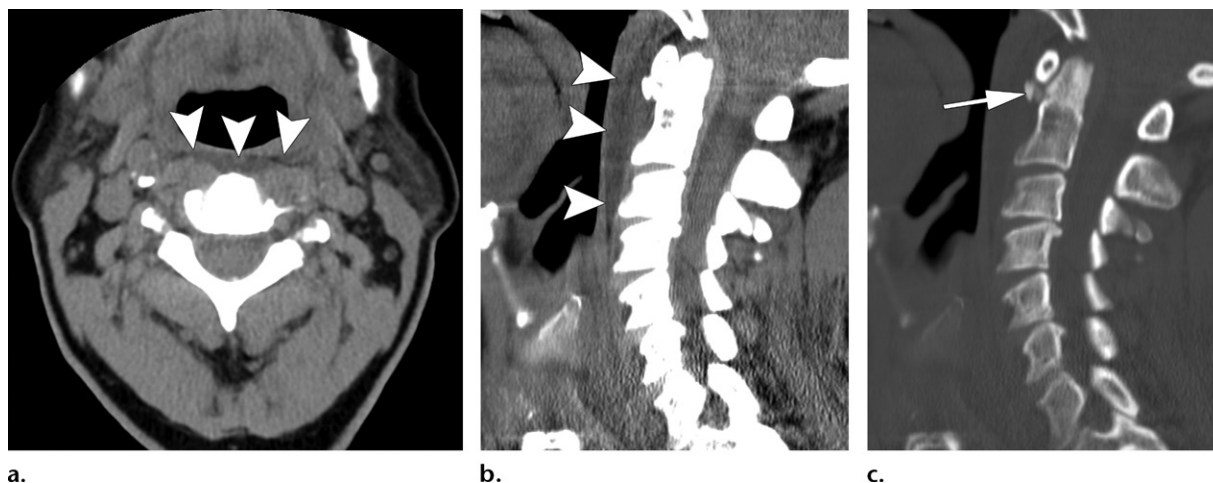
Retropharyngeal edema due to calcific tendinitis of the longus colli in a 71-year-old woman. (a, b) Axial (a) and sagittal (b) nonenhanced CT images show retropharyngeal edema (arrowheads). Note the tapered superior and inferior margins in b. (c) Sagittal nonenhanced CT image (bone window) shows calcification (arrow) inferior to the anterior arch of C1, in the typical location for calcific tendinitis of the longus colli.
